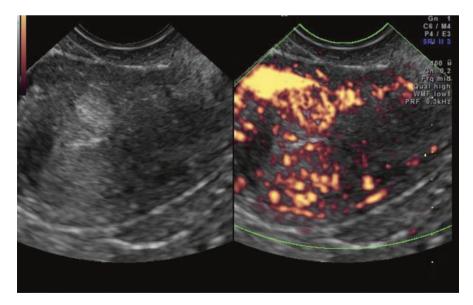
Thin endometrium on day 3 of the cycle shows subendometrial vascularity on power Doppler, indicating poor endometrial receptivity. Though in this case myometrial heterogenecity and vascularity is also seen anteriorly suggestive of adenomyosis
